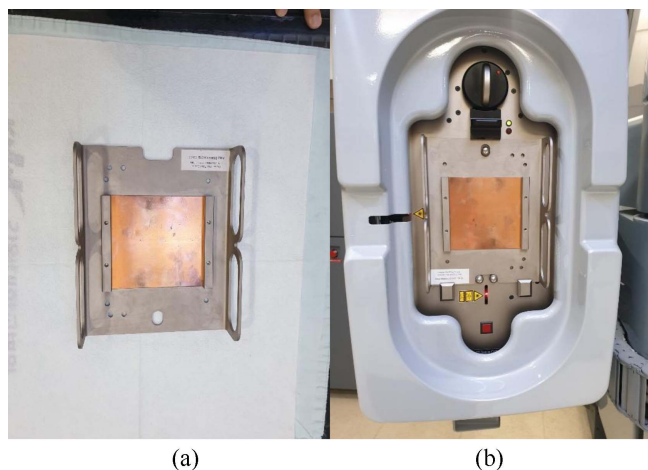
(Color online) A copper filter (a) and kV X-ray generator (b) for dual-energy modulation.
